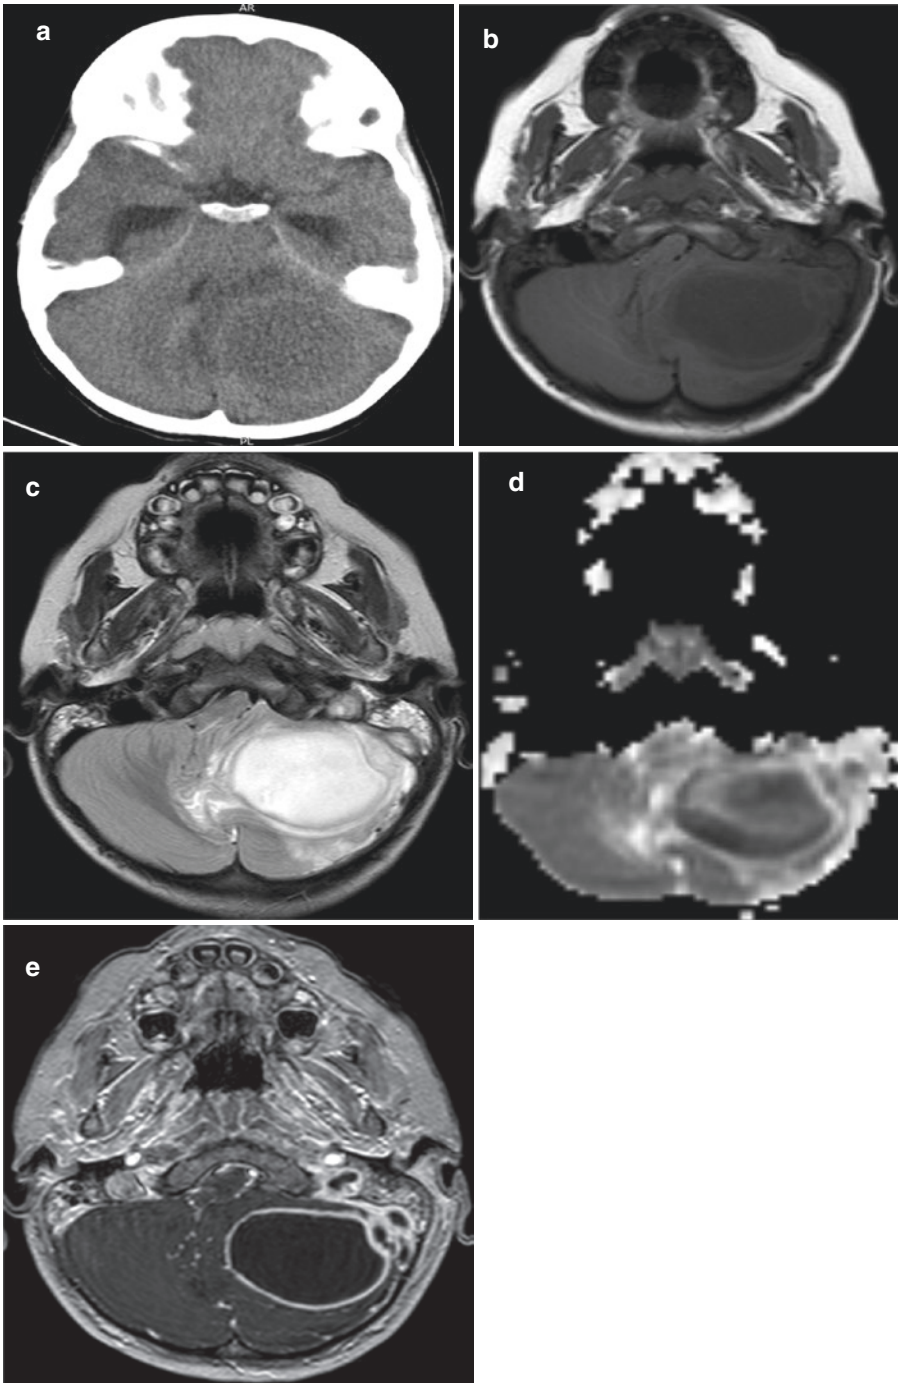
Cerebellar abscess. (a) CT scan. Presence of a left cerebellar hypodense mass, surrounded by edema, compressing e displacing the fourth ventricle; note temporal horn dilation. (b and c) T1 and T2-w axial sections; (d) ADC map axial section; (e) T1-w axial section after intravenous contrast medium injection. Presence of an oval-shaped mass with a central T1 hypointense, T2
